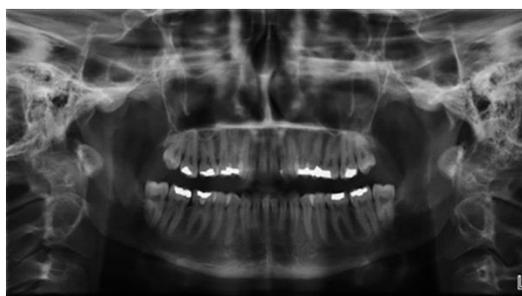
"Too far forward" positioning error was detected in this panoramic radiography.
